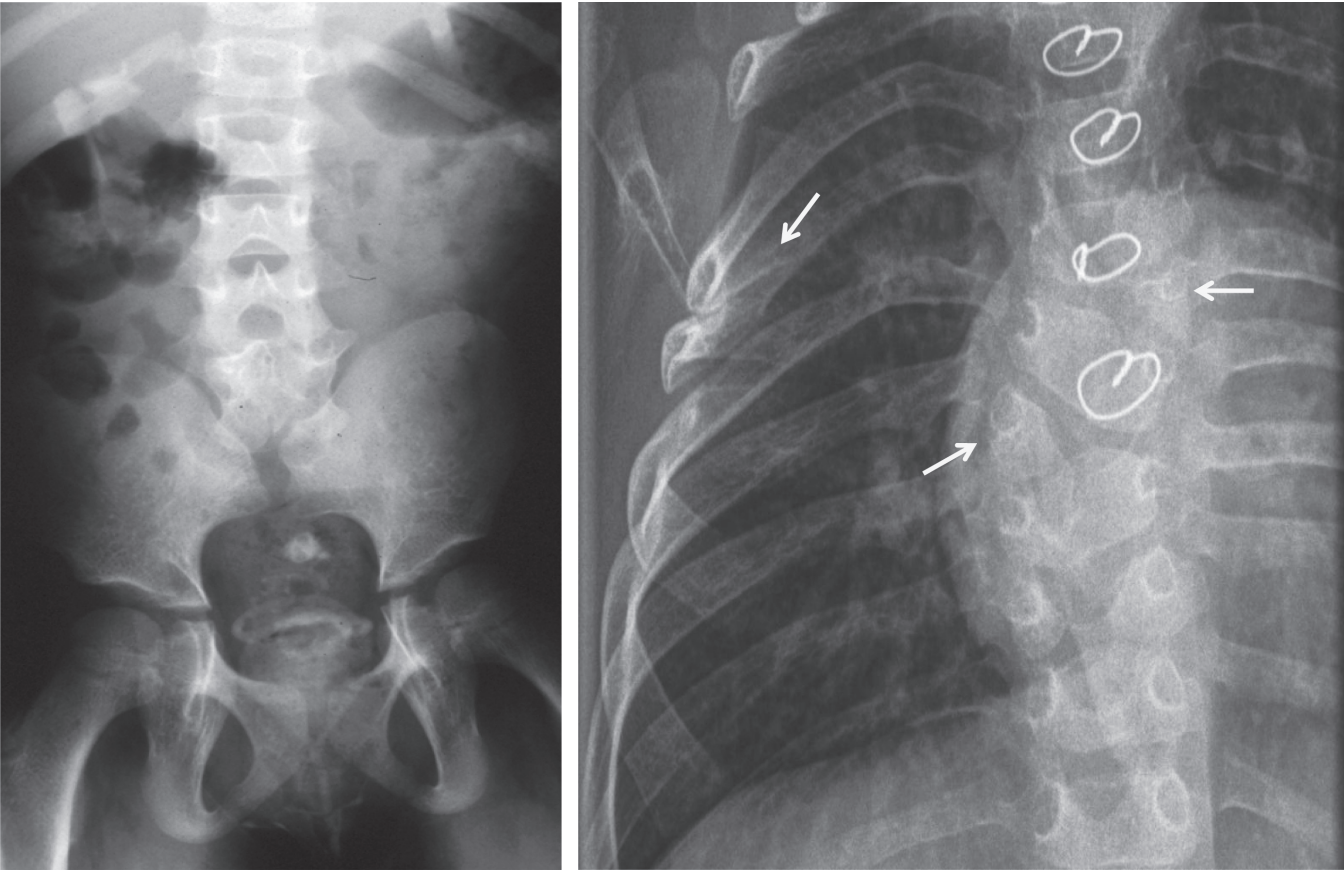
Examples of diabetic embryopathy. Left: sacral agenesis in a child whose mother had poorly controlled T2DM at conception. Affected children can have spina bifida-like features with difficulties walking and bowel and bladder dysfunction. Right: chest radiograph from an infant of a mother with T1DM. The child had cardiac surgery at age 7 months for double outlet right ventricle. Note also the two hemivertebrae and the fused ribs (arrowed).
